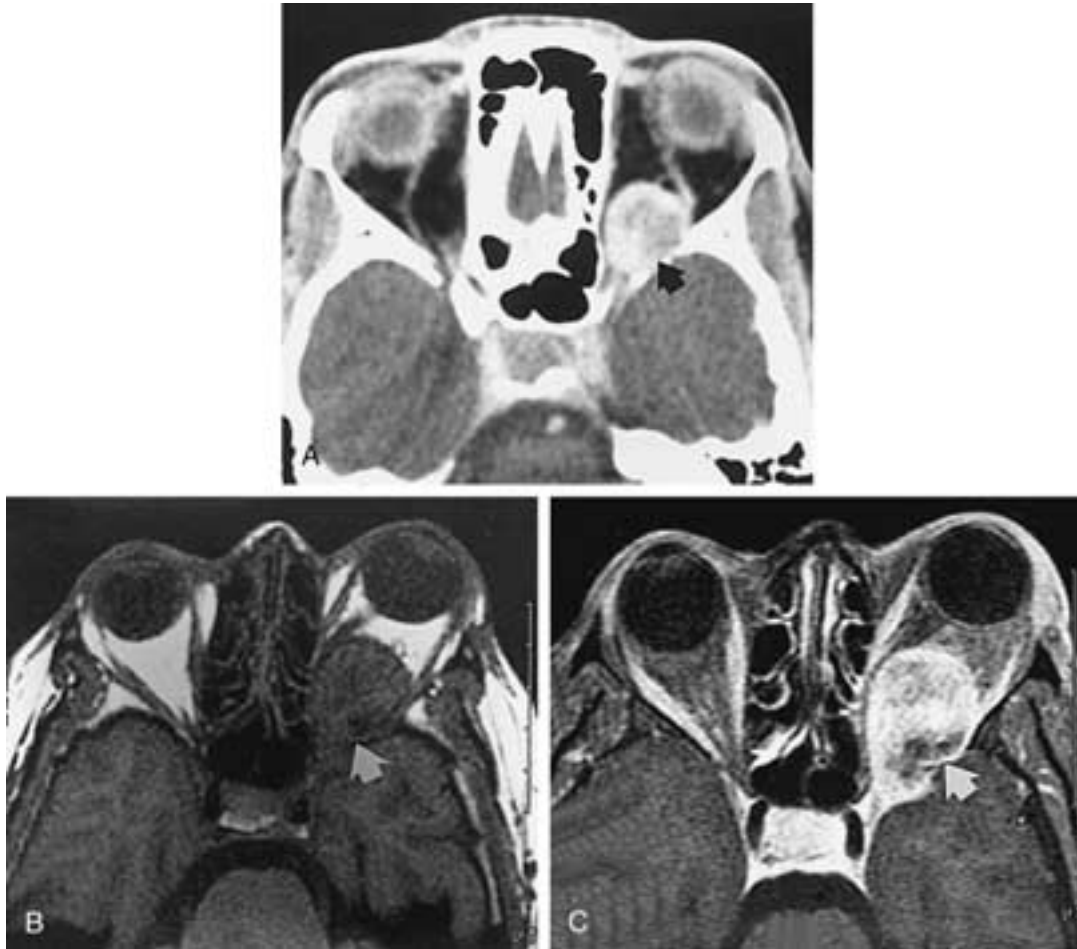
A, Postcontrast axial CT scan demonstrating a well-enhanced intraconal neurofibroma (*arrow*) of the posterior orbit. B, Axial T1-weighted MR scan of a posterior neurofibroma (*arrow*) as in A. Tumor is isointense to brain and hypointense to orbital fat. C, Axial fat-suppressed T1-weighted MR image of the tumor seen in A and B demonstrating the marked contrast enhancement of a posterior neurofibroma (*arrow*). (Courtesy of Mahmood Mafee, MD, University of Illinois at Chicago, Chicago, Illinois. From Carroll GS, Barrett GH, Fleming JC, et al. *Peripheral Nerve Tumors of the Orbit*. Radiol Clin North Am 1999 Jan;37(1):200.)
